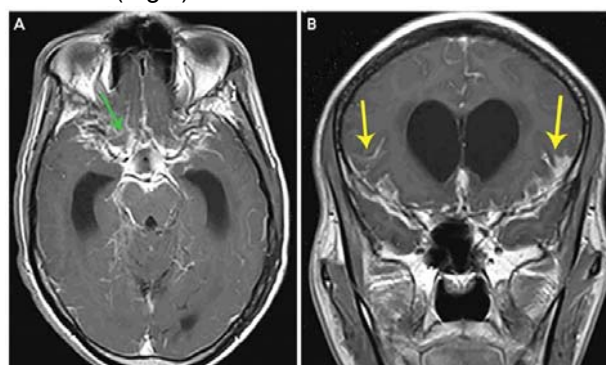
Axial (A) and coronal (B) postcontrast T1-weighted MRIs reveal a thick basal exudate (A, green arrow) in the basal cisterns and leptomeningeal enhancement (B, yellow arrows) in the frontotemporal regions bilaterally as well as communicating hydrocephalus.
